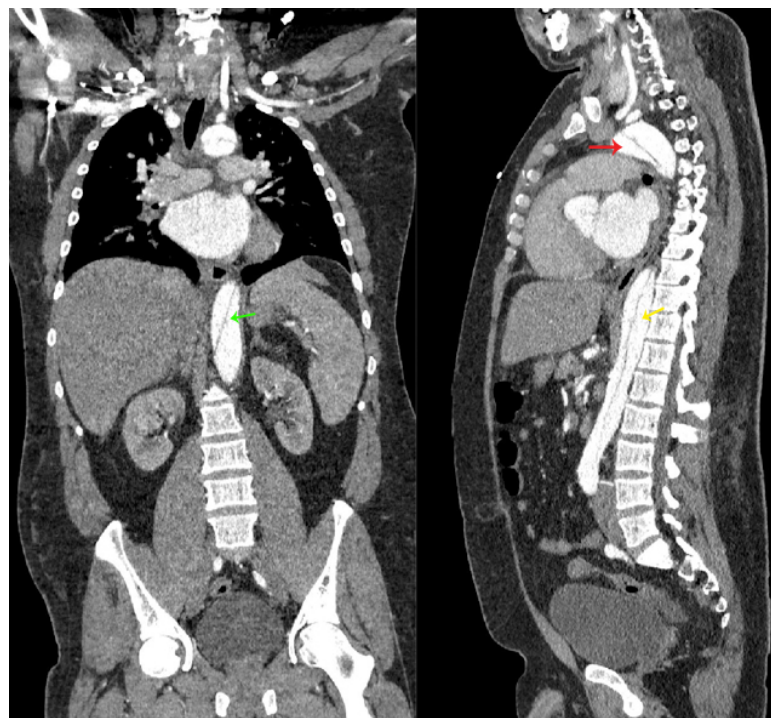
CT SCAN IMAGES FROM A 30-YEAR OLD MALE WITH AN ACUTE TBAD. THE GREEN ARROW INDICATES THE POSITION OF THE INTIMAL FLAP. THE YELLOW ARROW INDICATES THE FALSE LUMEN AND THE RED ARROW THE TRUE LUMEN.
